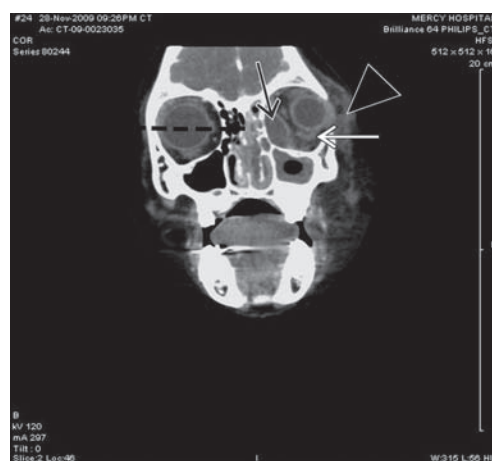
Coronal view of contrast-enhanced CT scan demonstrating (black arrow) extraconal orbital subperiosteal abscess with air-fluid collection along the medial and anterior walls of the maxillary sinus with (white arrow) associated lateral displacement of the left medial and inferior recti, (arrowhead) left preseptal cellulitis with proptosis, (dotted line) left maxillary and ethmoid sinusitis.
